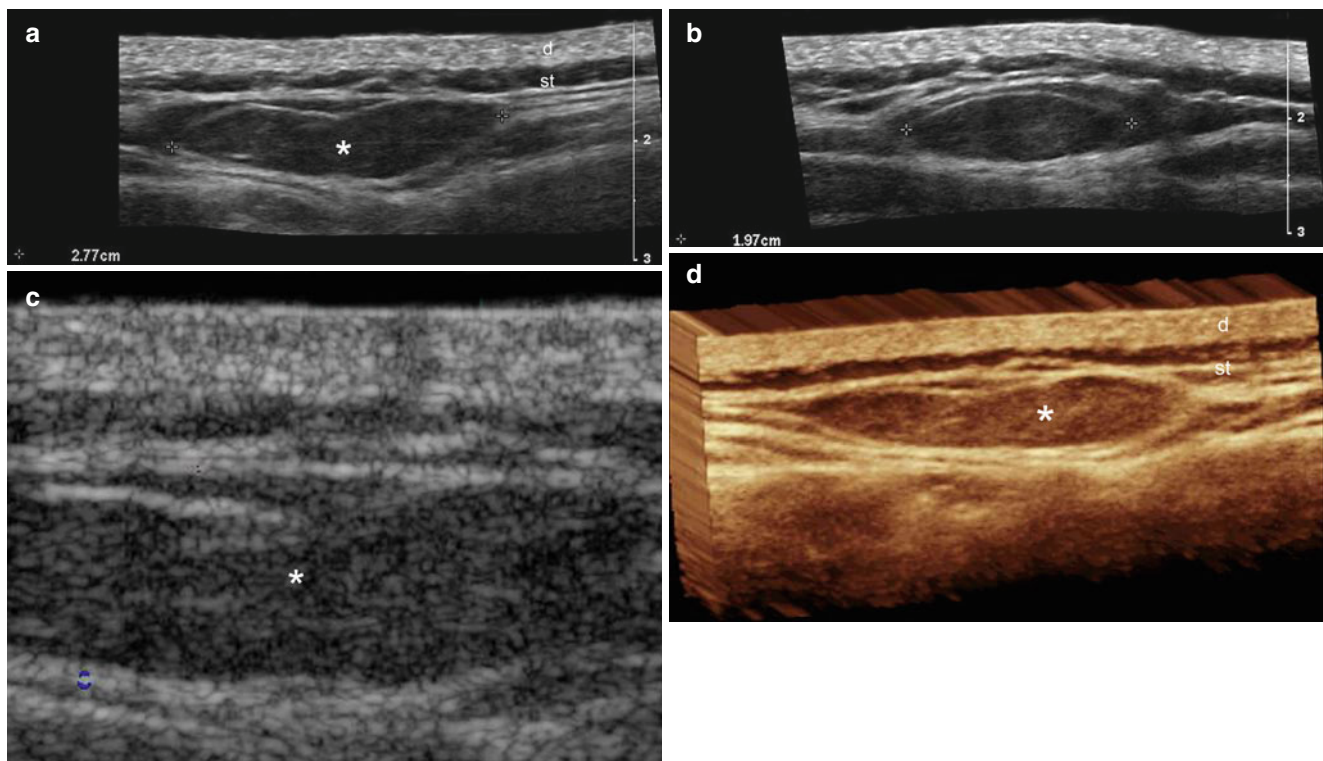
(a–d) Elastofibroma dorsi. (a, b) Grey scale ultrasound images (a longitudinal and b transverse view) show a 2.77 cm long × 1.97 cm transverse axis well-defined oval-shaped hypoechoic and slightly lobulated solid mass in the subcutaneous tissue of the left
